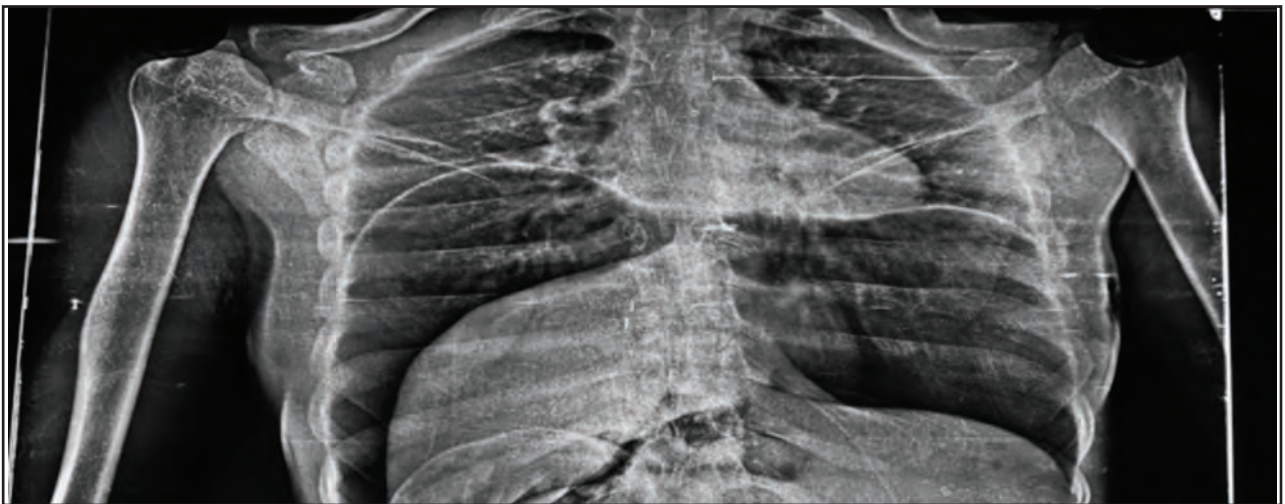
Chest xray showing air under diaphragm indicating and extensive hollow viscus perforation
